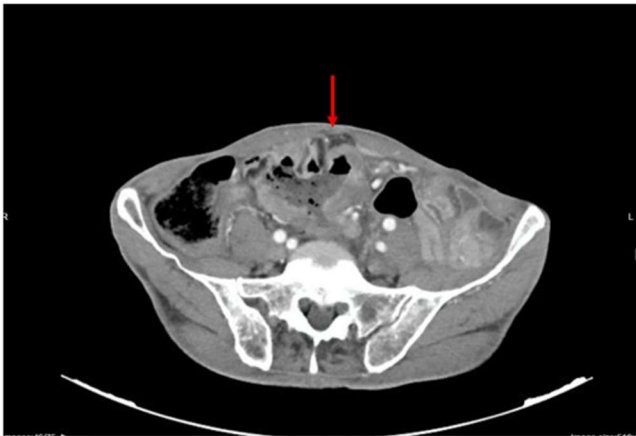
CT scan image showing an irregular circumferential tumoral process involving the small intestine, centrally located, causing acute intestinal obstruction with feces sign (arrow).
